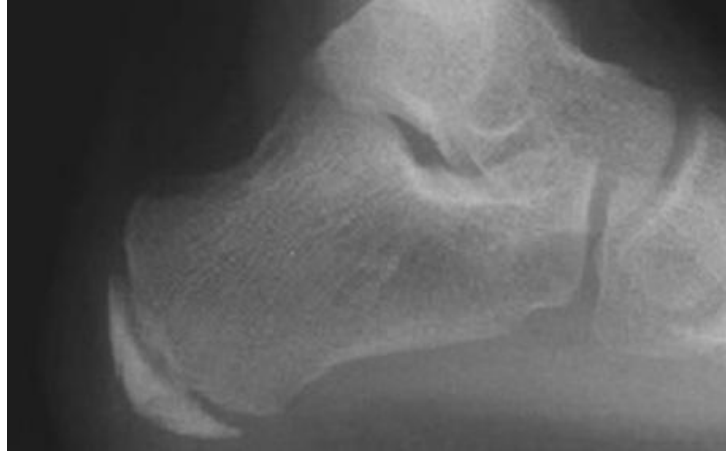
Radiography of a Sever's disease case. Adapted from e-radiography.net
